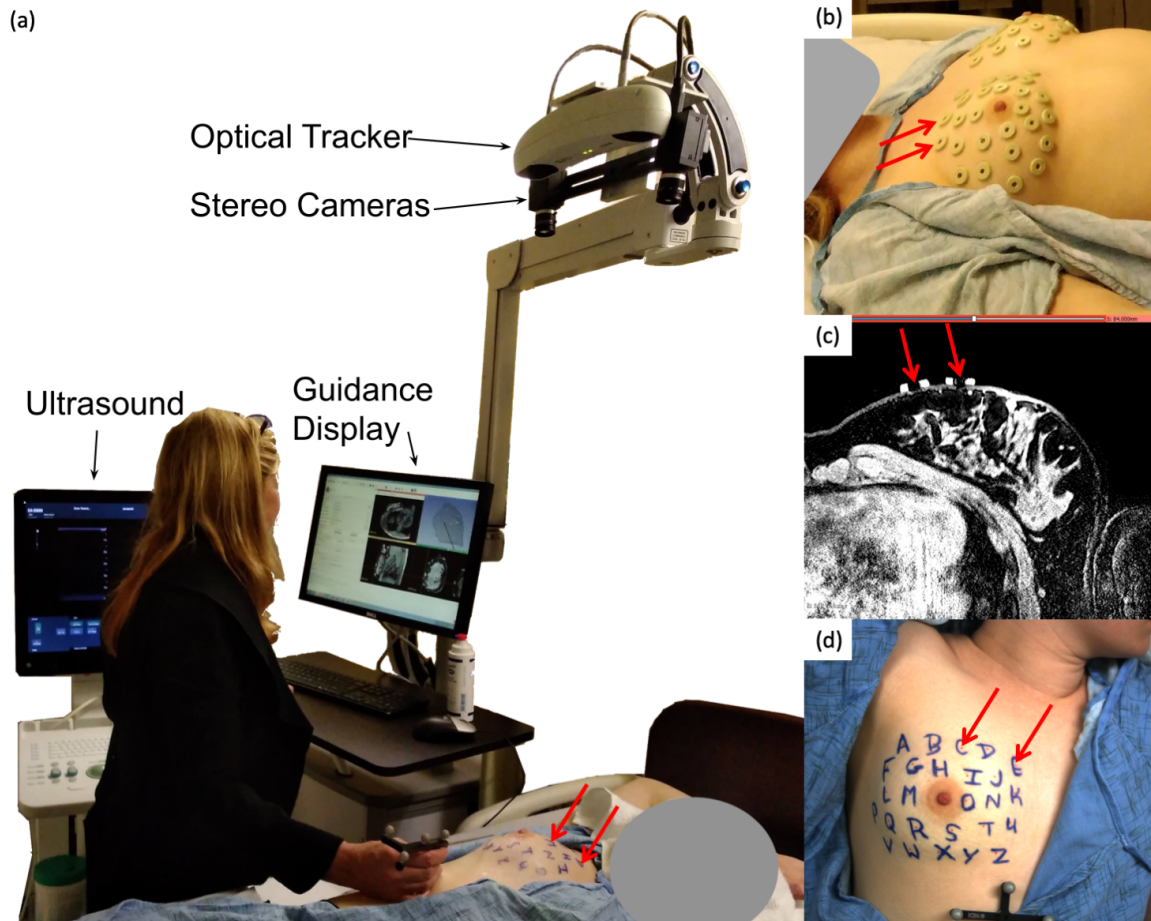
Data collection system and fiducial distribution. Red arrows indicate fiducial locations. (a) Data collection in the arm-up position with the rigidly coupled instrument tracker and stereo camera pair, ultrasound machine, and guidance display. (b) Twenty six MR visible fiducials distributed across each breast. (c) Two fiducials visible on an axial slice of a supine MR image. (d) Anterior view from one RGB camera in the mock intraoperative setting; the center of each MR fiducial marked with red ink, and labeled with a blue hand drawn letter.
